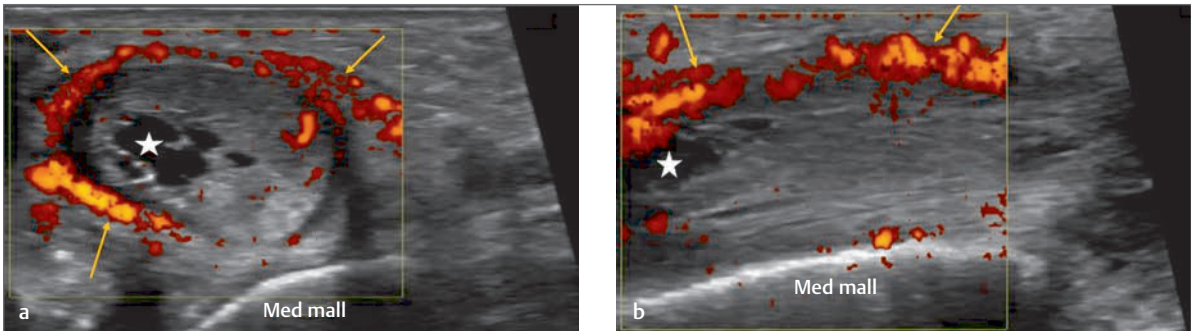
(a,b) Transverse and longitudinal scan, respectively, of the tendon of tibialis posterior demonstrating a marked tendinopathy with a central anechoic region within the tendon indicating an intrasubstance tear (white stars). In addition, there is a marked tenosynovitis noted within the tendon sheath (yellow arrows) which is further highlighted with Power Doppler imaging. Med Mall, medial malleolus; white star, anechoic tear within the substance of tibialis posterior tendon; yellow arrows, evidence of a tenosynovitis within the tendon sheath.
